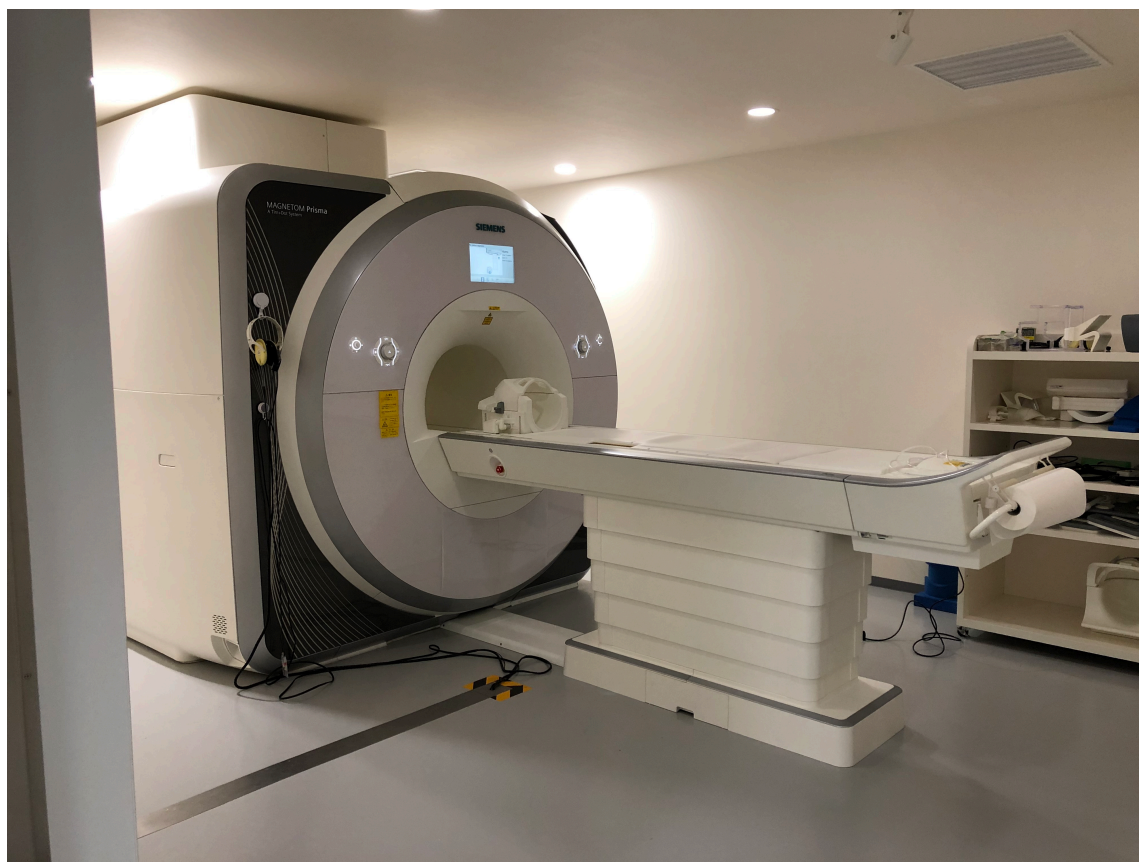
Example of MRI scanner (Siemens, Germany)
